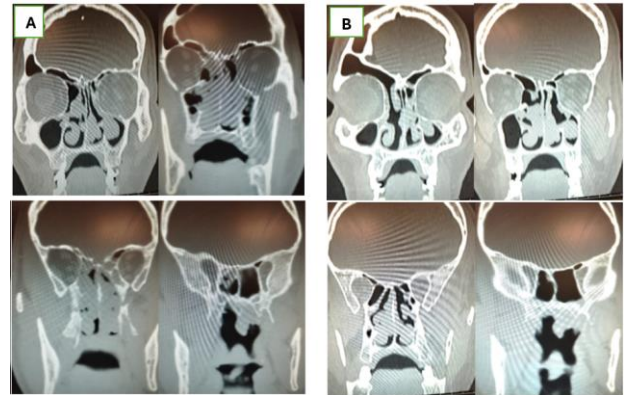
A: CT scan for a case with Lund Mackay score 14 before administration of dupilumab. B: CT scan for the same case with Lund Mackay score 6 after 6 months of administration of dupilumab
